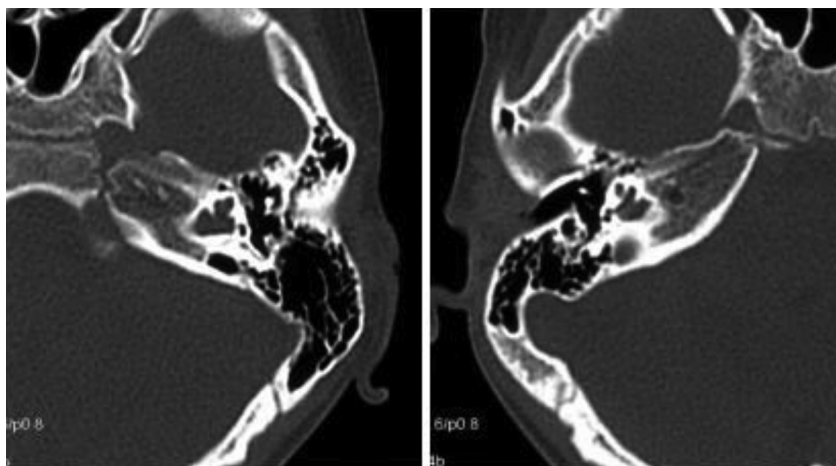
Temporal bone CT scan of the proband.
